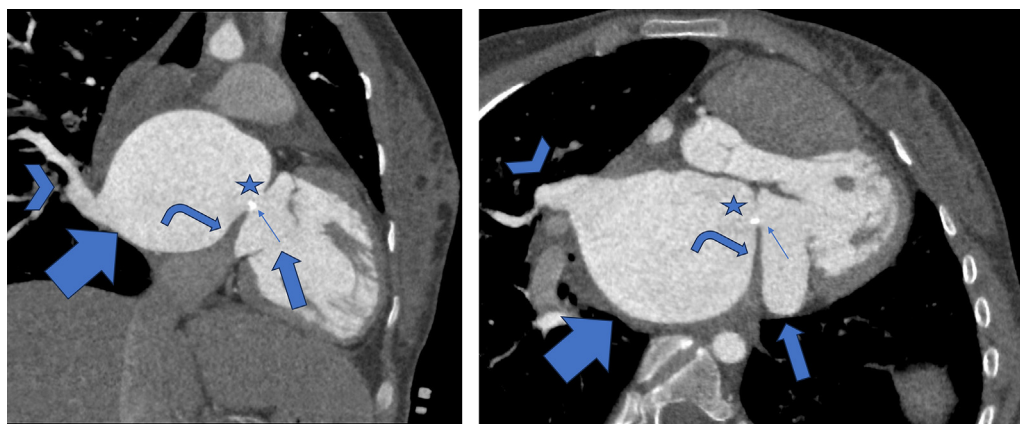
Two images of cardiac CT scans, axial and oblique sagittal views, show a fibromuscular membrane (curved arrow) with internal fenestration (star) and a focus of calcification (thinnest arrow), dividing the left atrium into 2 chambers, a proximal chamber (thick arrow) containing the pulmonary vines (arrowhead), and a distal chamber “true” left atrium (thin arrow) containing the left atrial appendage.
